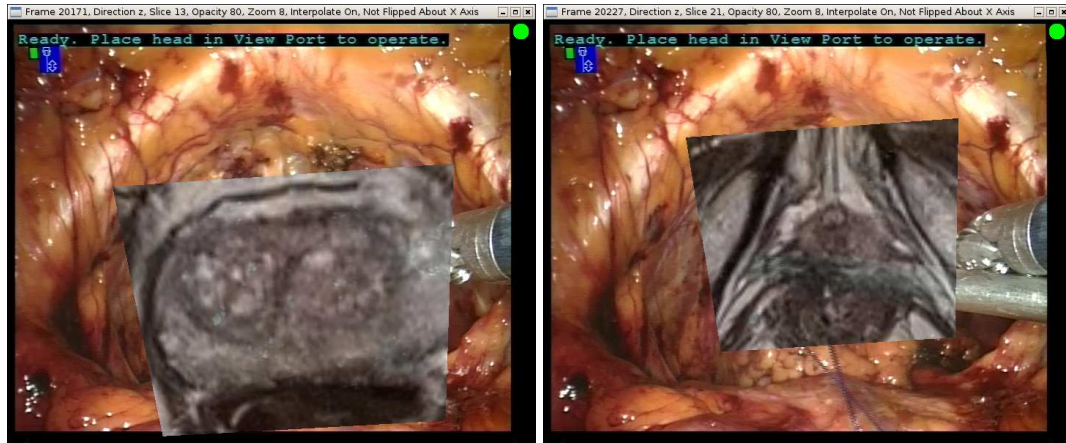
Different slices from the MRI can be selected interactively. The image at right shows a slice 8 slices further away (inferior) to the image at the left
